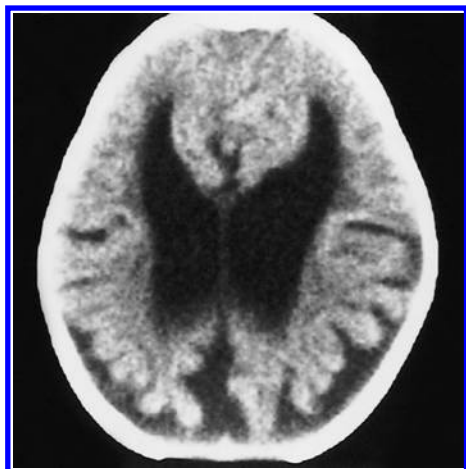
EB: Computed tomography scan at ten months. There was appreciable cerebral atrophy.
